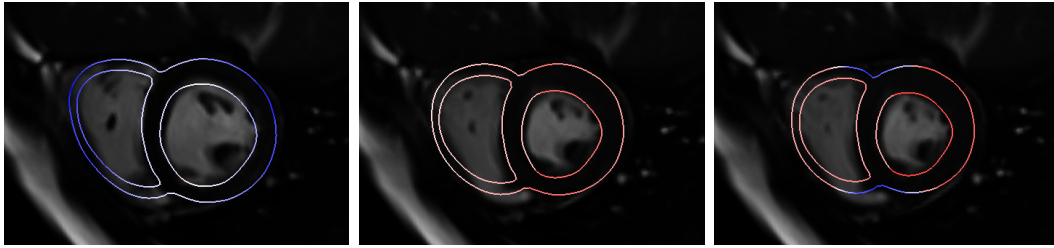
Qualitative goodness of fit between cine MRI acquisition and motion computed by the model. Contours overlaid on top of the short-axis image slice represent cut through the computed myocardium surface at three different time points, from diastole (left) to peak-systole (right). Computed motion and images fit qualitatively well throughout the heart cycle. Colors encode active cell force (red is strongest).
